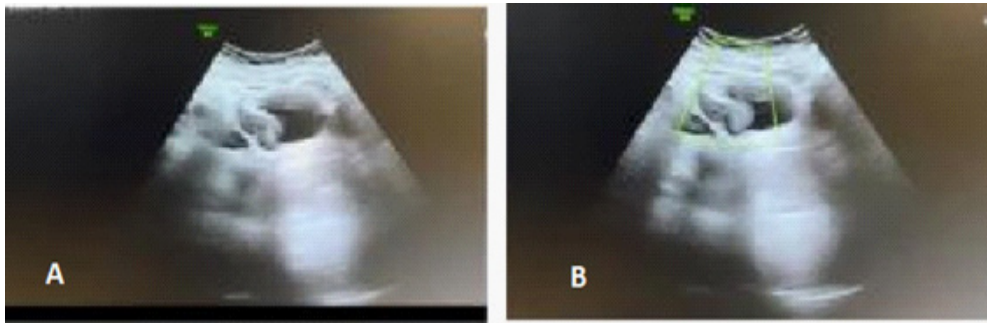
In the transverse view of grayscale (A) and color Doppler sonography (B) there is a focal wall thickening in the anterior and right lateral wall of the bladder without obvious vascularity.
